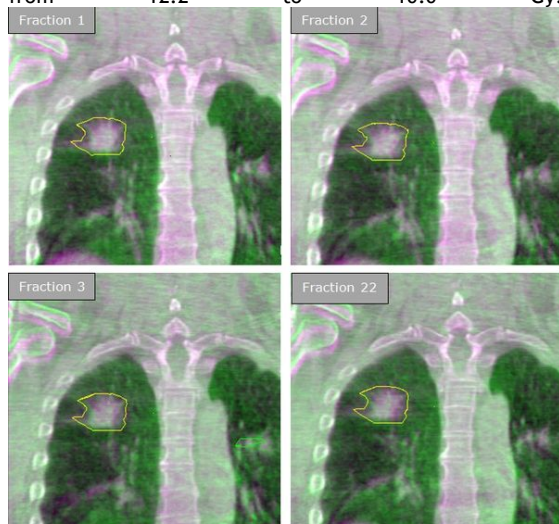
Result of registration of bony anatomy of CBCT (green) onto planning CT (magenta) for a typical non-mover. Obviously, bony anatomy registration already puts the tumor near to its intended position (yellow contour indicates the planning CT ITV) both at the beginning and near the end of treatment.
